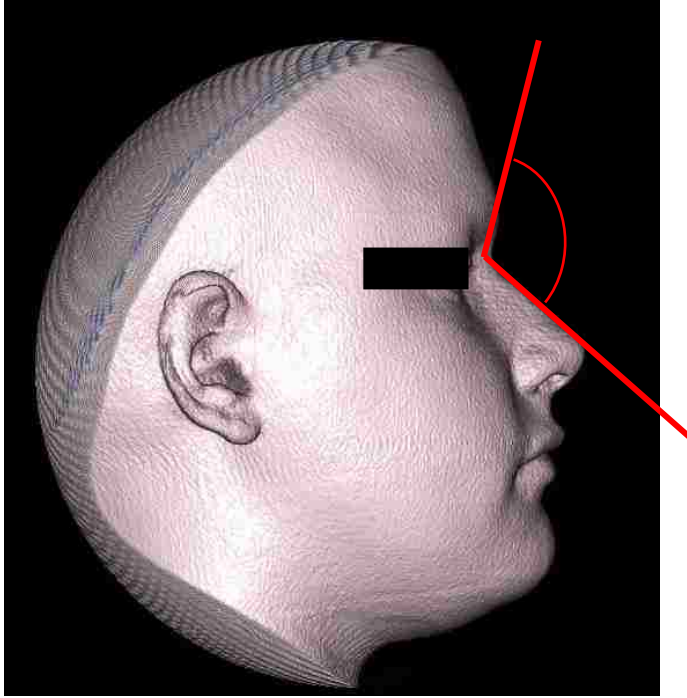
Nasofrontal angle (derived CBCT using Invivo 5.3 Software)*
